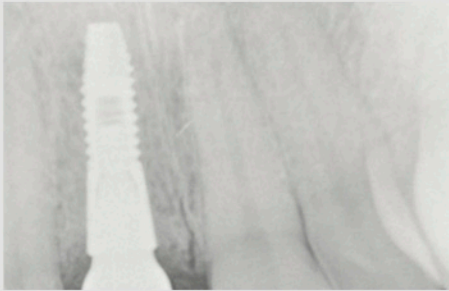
Six weeks after implant placement, a radiographic confirmation of implant integration was taken. Note the preservation of crestal bone.
